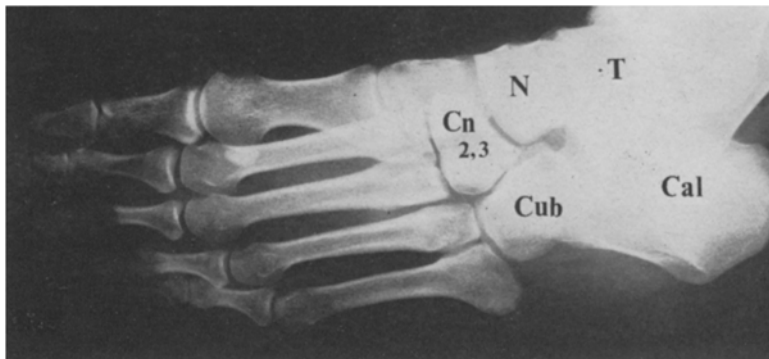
Oblique roentgenogram of the foot. T, os talus; N, os naviculare pedis; Cal, os calcis; Cub, os cuboideum; Cn 2, 3, os cuneiforme intermedium and os cuneiforme laterale. Synostosis among the os talus, os naviculare pedis, os calcis and os cuboideum, that between the os cuneiforme intermedium and laterale, and that between the middle and terminal phalanges of the 4th and 5th toes are observed.
